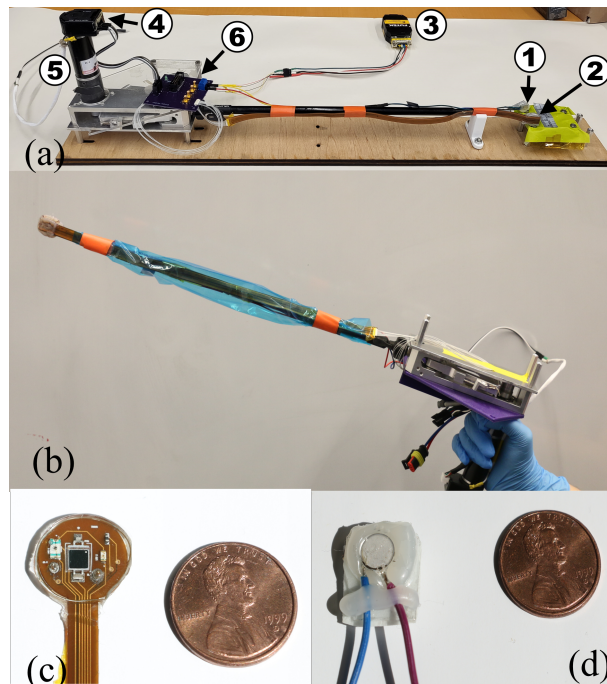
(a) Smart Grasper instrument inverted on a test bench: (1) 3 MHz Steminc SMD063T07R111 1D ultrasound transducer, (2) NCP15XH103J03RC 10 k $\Omega$  thermistor, (3) Futek amplifier for FT1010 force sensor, (4) Maxon HEDL-5540 encoder, (5) Maxon RE25-10W motor, (6) Futek FT1010 40 lb force sensor. Motor body serves as a handle for the user. (b) The Smart Grasper Instrument in use. (c) Sensor set on flex pcb with epoxy cover to protect sensors from moisture. It includes: thermistor, IR and RED LEDs, two electrodes and photodiode. (d) 3 MHz Steminc SMD063T07R111 1D ultrasound transducer was epoxied to protect it from moisture.
